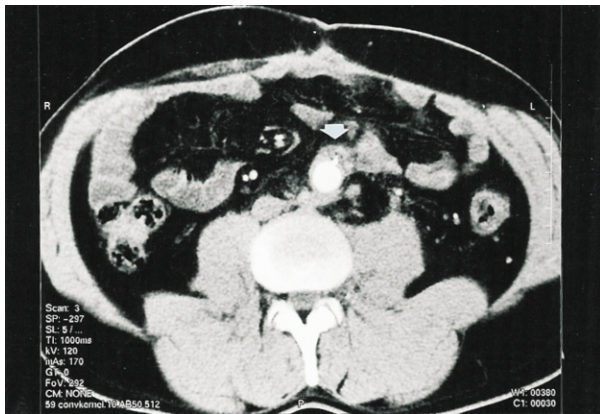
CT scans at 3, 6, and 9 months revealed a good function of the graft without any signs of infection covered by the muscle flap (arrow).
